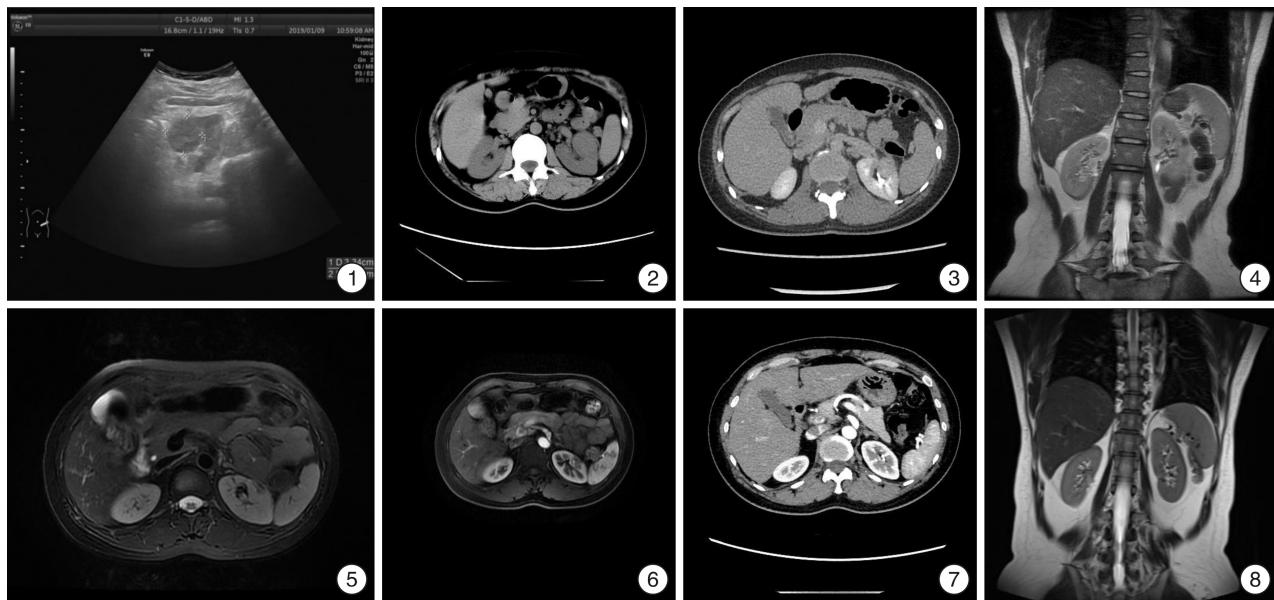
患者初次就诊时彩超表现; 图 2 患者初次就诊时 CT 表现; 图 3 抗感染治疗 10 d 后增强 CT 表现; 图 4~6 患者首次出院 2 个月后复查肾脏 MRI 表现; 图 7 患者二次出院后 14 个月肾脏 CT 表现; 图 8 患者二次出院后 22 个月复查肾脏 MRI 表现
